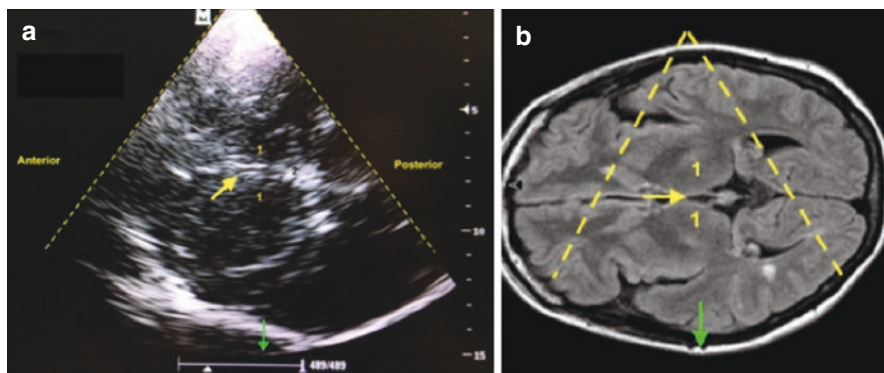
(a) Diencephalic plane by TCCS through transtemporal acoustic window: (1) Thalamus. (2) Pineal gland, (yellow arrow) 3rd ventricle and (green arrow) contralateral skull. (b) Brain MRI: (1) Thalamus, (yellow arrow) 3rd ventricle, (dotted line) ultrasound beam through transtemporal window and (green arrow) contralateral skull
